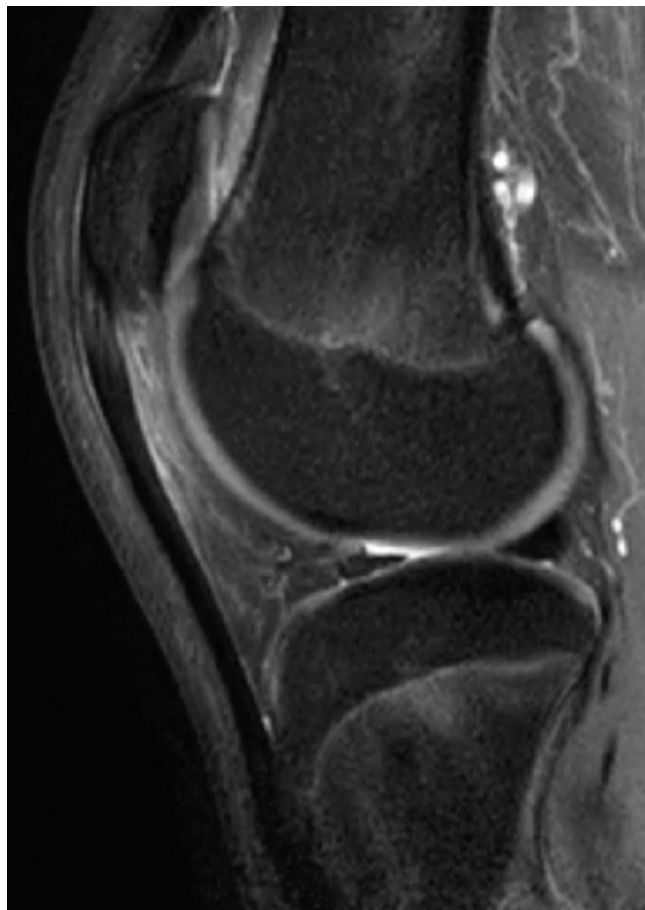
Sagittal MRI image showing Hoffa's fat pat impingement due to patella alta.
